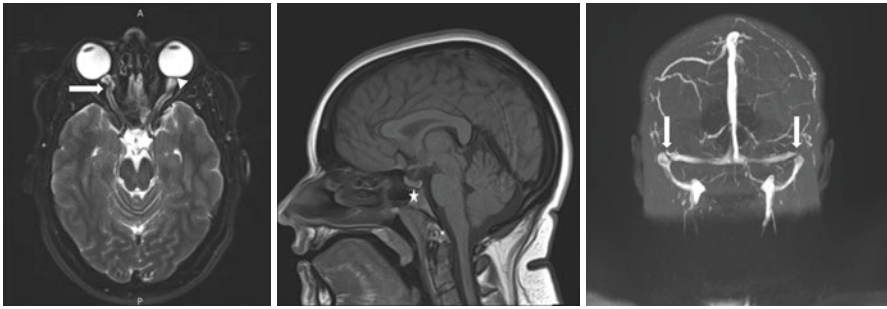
MRI findings of elevated intracranial pressure. (Left) T2 fat-saturated axial image showing dilated and tortuous optic nerve sheaths (arrow) and posterior globe flattening (arrowhead). (Middle) T1 sagittal image showing concave pituitary gland as a forme fruste manifestation of empty sella (star). (Right) Coronal MR venogram showing bilateral transverse venous sinus stenosis (arrows). (© AR Carey 2020. All Rights Reserved)
